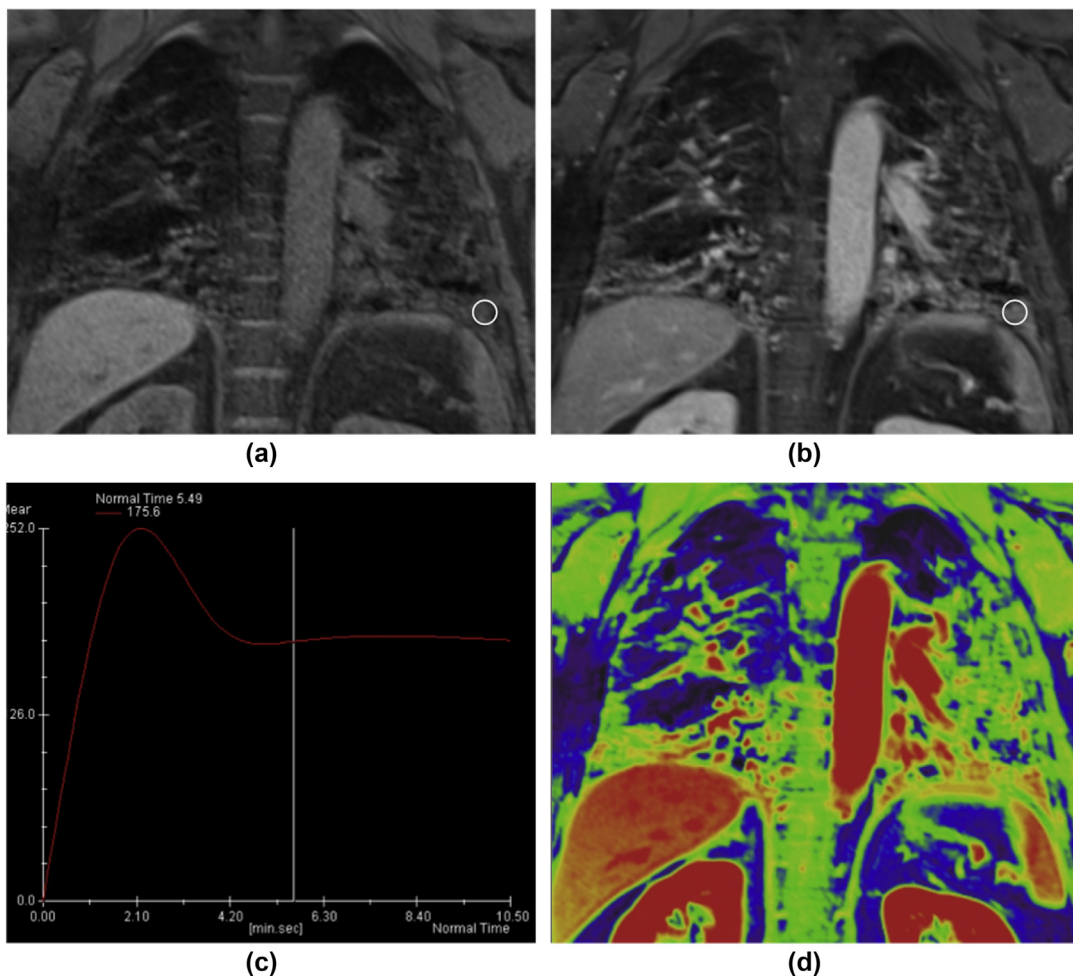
Dynamic contrast-enhanced MRI may contribute to the differentiation between inflammatory- and fibrotic-predominant interstitial abnormalities. In a patient with IPAF, coronal GRE fat-saturated T1-weighted images before (a) and after gadolinium administration (b) show enhancement of interstitial reticular abnormalities. Dynamic MRI (images acquired at 1, 3, 5, and 10 minutes) demonstrates early enhancement and washout (c) of the interstitial reticulation, suggesting inflammatory-predominant abnormalities (circles in a and b indicate the region of interest). Colour contrast scale (d) allows prompt detection of areas of maximum contrast enhancement.
